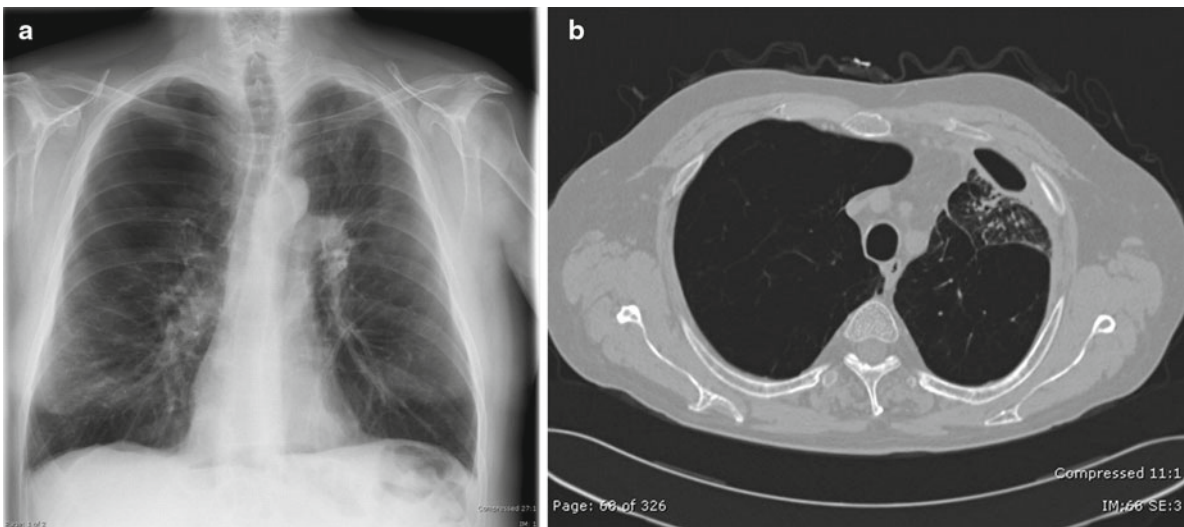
(a) X-ray and (b) CT after 6 weeks of rising the pigtail twice/day and 6 weeks follow-up
